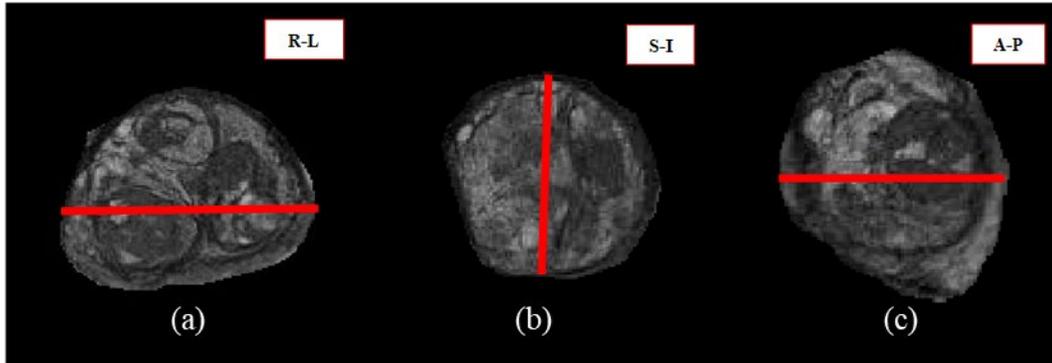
Volume measurement of the ellipsoid prostate on triplane (a) axial, (b) coronal, (c) sagittal. T2W MRI images using the formula right-to-left (R-L) diameter, anterior-posterior (A-P) diameter, and superior-inferior (S-I) diameter.
